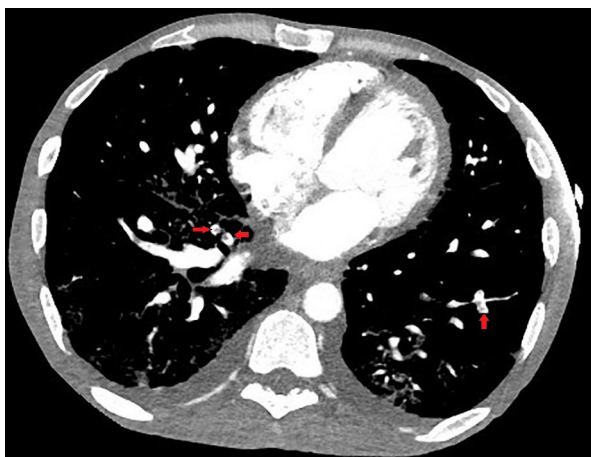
CT pulmonary angiogram showing multiple filling defects in right anterior descending and left posterior descending branches of pulmonary arteries.
